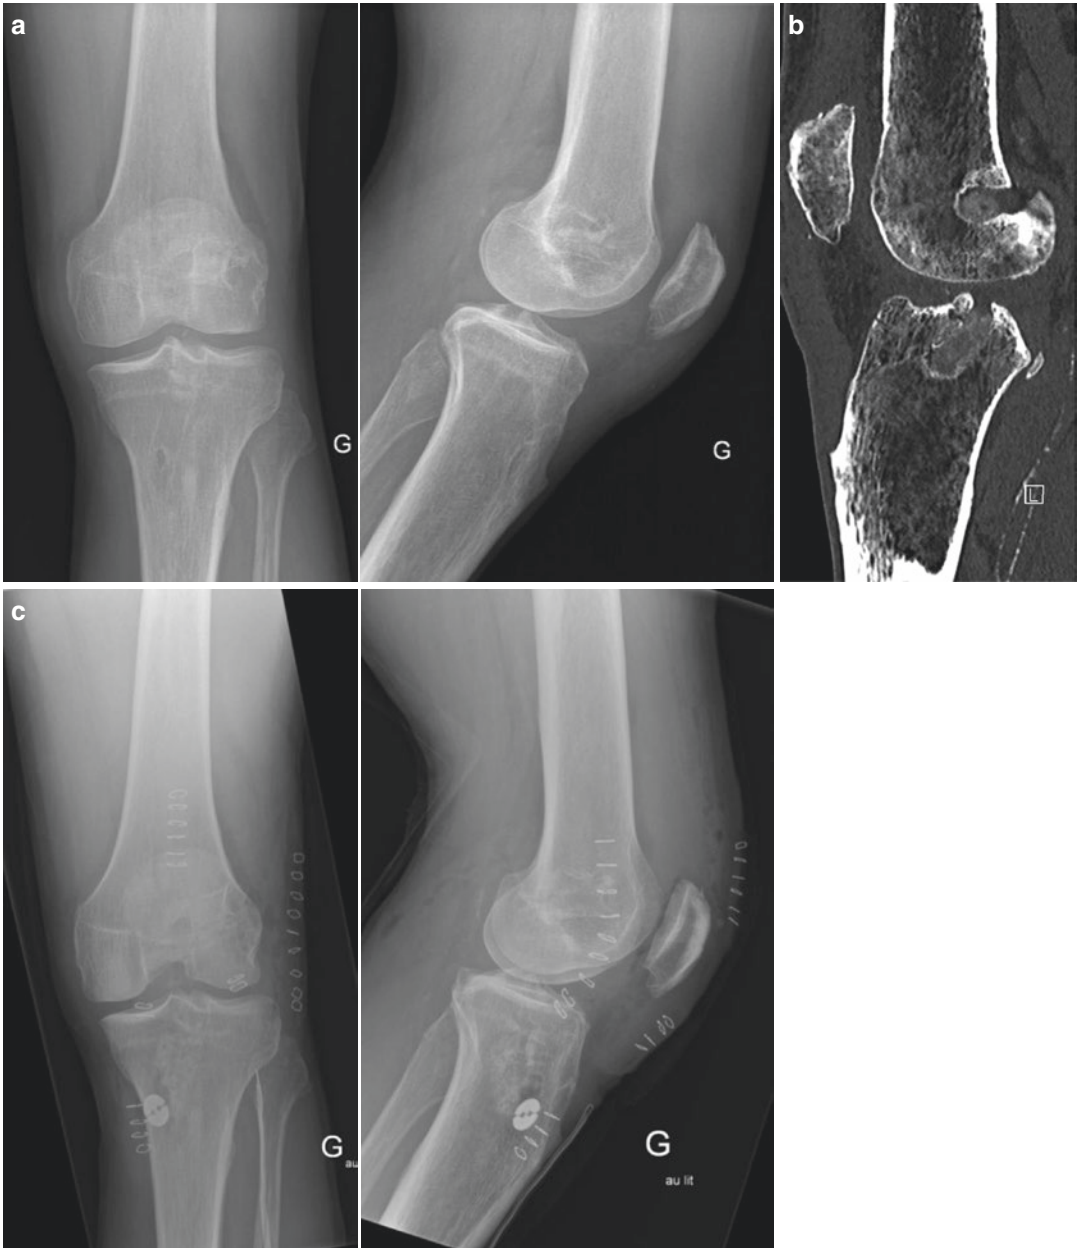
The radiological evaluation of bone tunnel placement. (a) X-ray shows a posteriorly placed tibial tunnel placed. In this case, we decided to perform staged surgery in order to be able to safely place the tibial tunnel and to assure a good fixation. (b) CT image after first step surgery for bone grafting. In this particular case, you should
